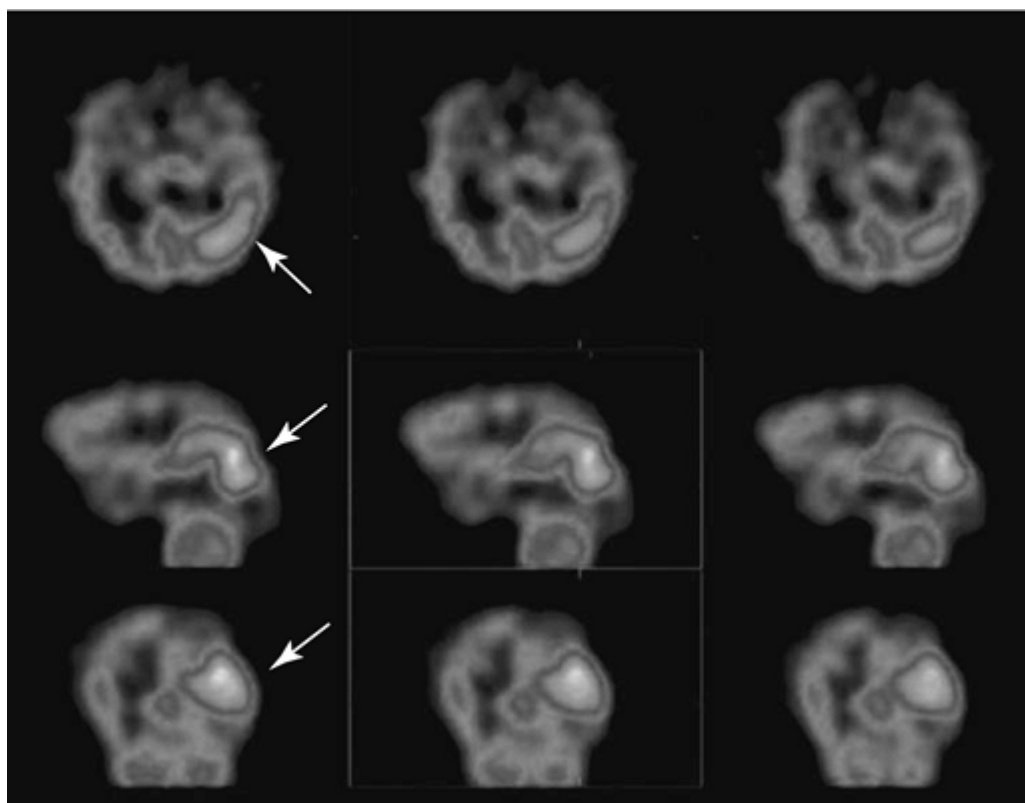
Injection of a single photon emission computed tomography radioligand during a seizure can show dramatic focal increase in perfusion in the posterior temporal region, suggesting seizure origin in this area.
